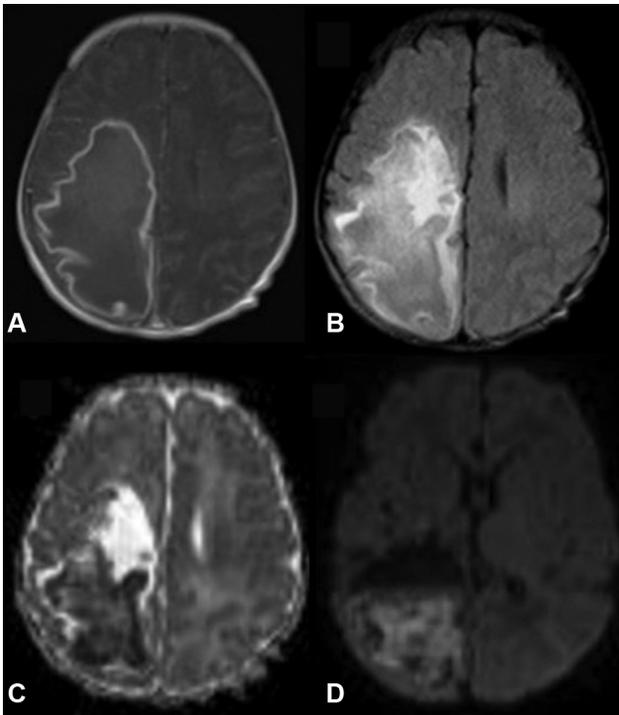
MRI axial view: A. T1-weighted gadolinium enhanced B. Fluid-attenuated inversion recovery (FLAIR) C. Apparent diffusion coefficient (ADC) D. Diffusion weighted imaging (DWI) revealing an extensive right fronto-parieto-occipital abscess.
